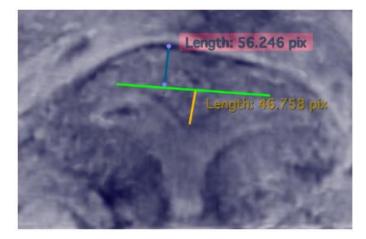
Three dimensional ultrasound showing uterine wall thickness in blue measuring approximately 5.6 mm
